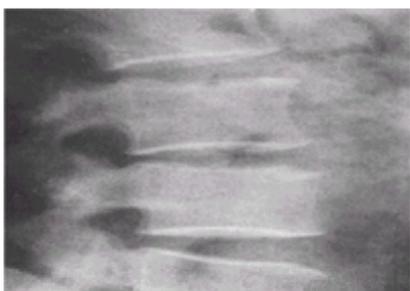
Lateral radiograph of lumbar vertebrae, showing an upper corner lesion, with sclerotic base (Pedro Pons' sign), considered characteristic of brucellar spondylitis. Diminution in the height of the disc space is also seen.
